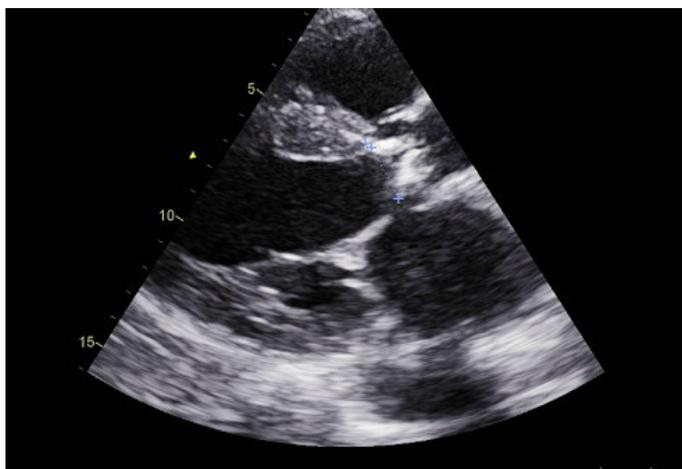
Image of two-dimensional echocardiography left parasternal long axis showing thickened and very calcified aortic sigmoid.
